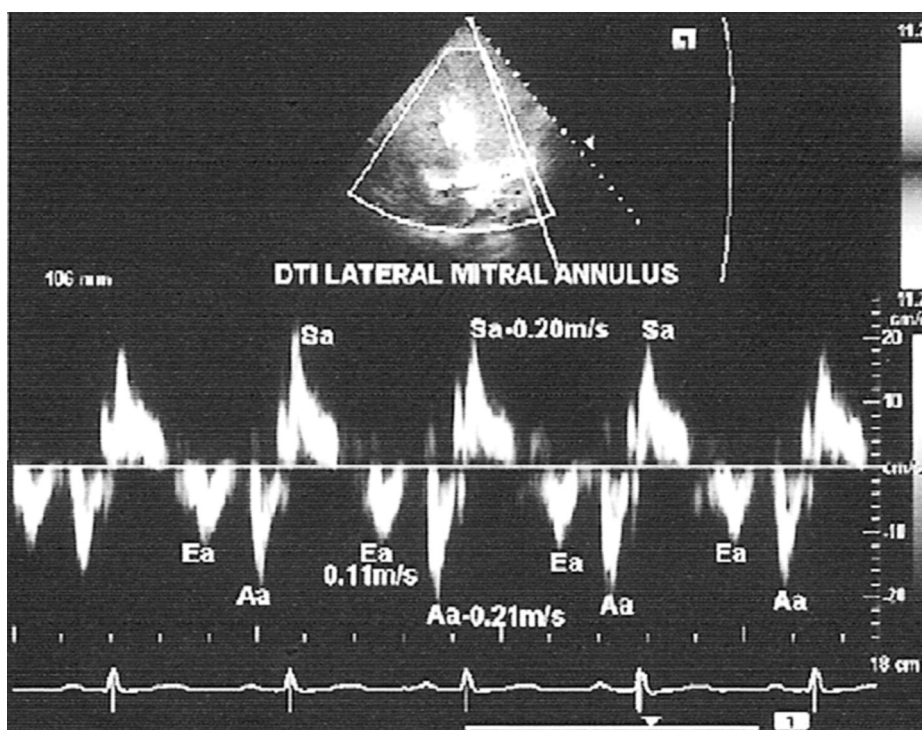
Tissue Doppler imaging of lateral mitral annulus. Aa – velocity during atrial systole, Ea – early relaxation velocity, Sa – systolic velocity.
